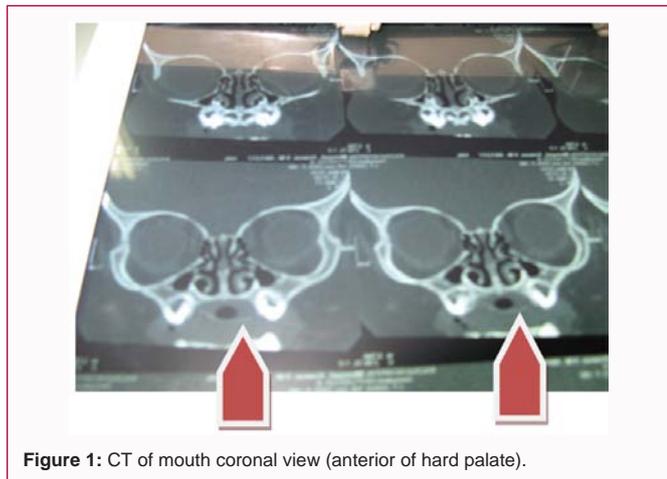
CT of mouth coronal view (anterior of hard palate).
